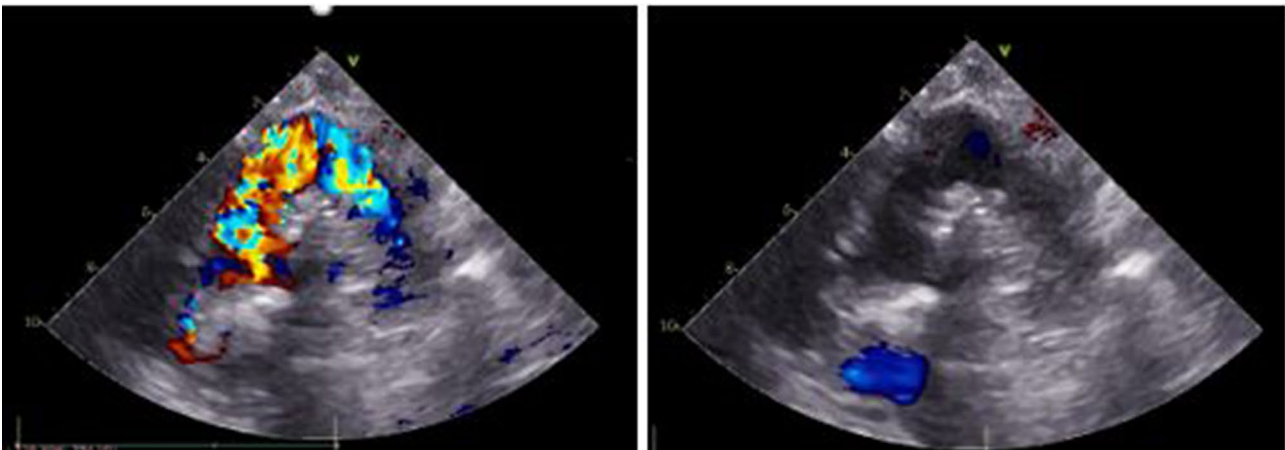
Control echocardiography 3 months after surgical procedure. Reconstruction of the ascending aorta with a 22 mm Dacron tube. Maximum gradient in the ascending aorta was 16 mmHg and mean of 8 mmHg. Pulsatile flow in the descending aorta without stenosis
